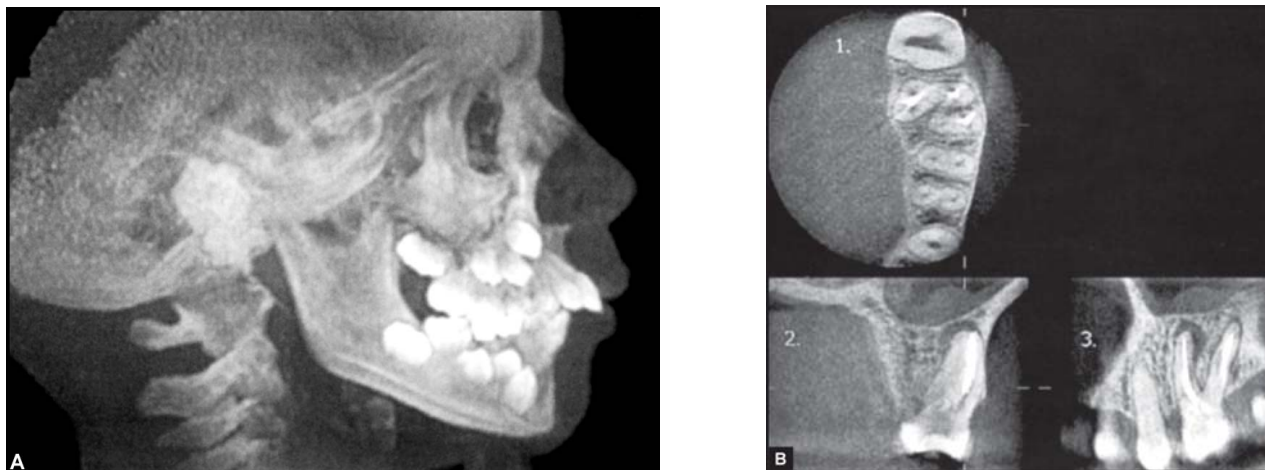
Cone Beam Computed tomography. Multiplanar reformatting of the primary image reconstruction allows for images of any body plane to be made.
